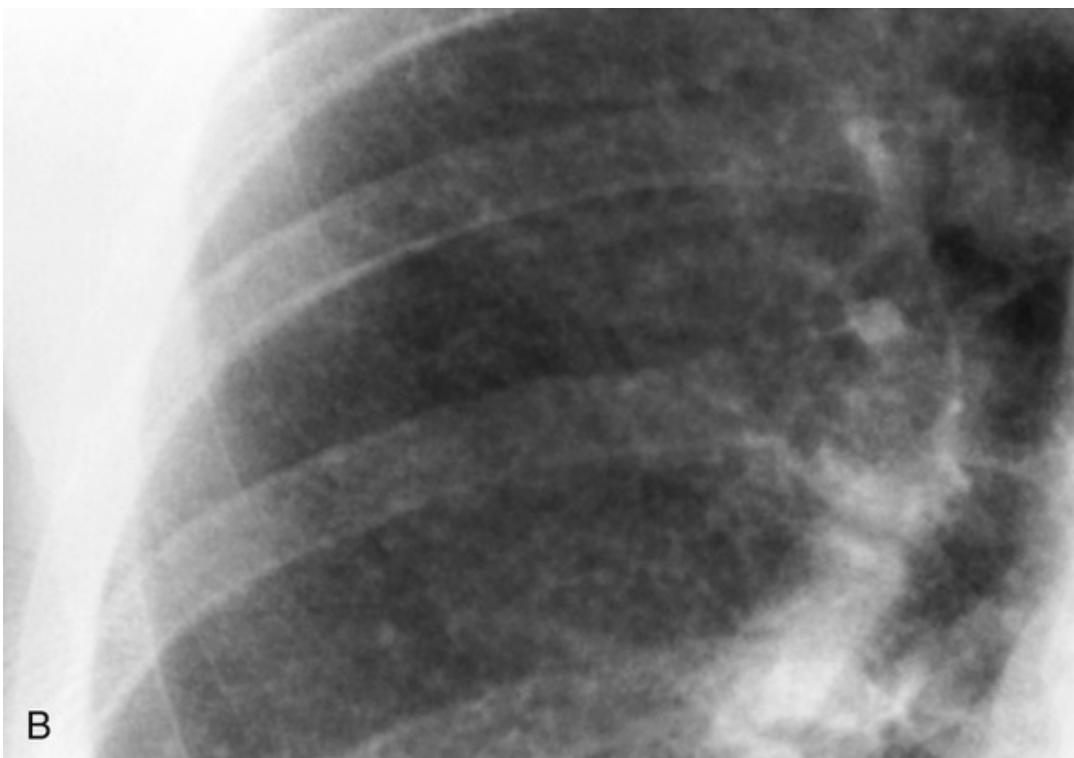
Chest x-rays of a 32-year-old man with immunodeficiency.
